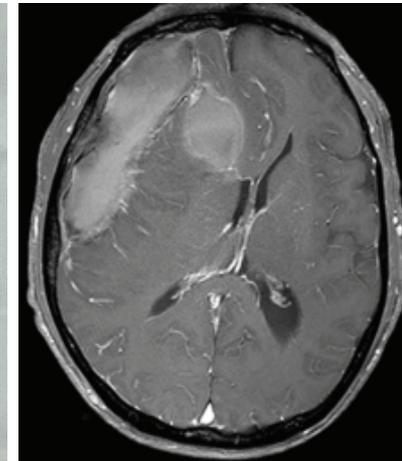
MRIs demonstrating a subdural collection and its thick, intensely enhancing capsule with adjacent meningeal-pial enhancement in an 8-year-old girl with brucellosis. *a*: axial proton density MRI. *b*: T₂-weighted MRI. *c*: enhanced axial MRI. *d*: T₁-weighted MRI. The adjacent diploic bone thickening (*arrows*) suggests chronicity (figure 1c). Note the dilatation of the contralateral ventricle.
